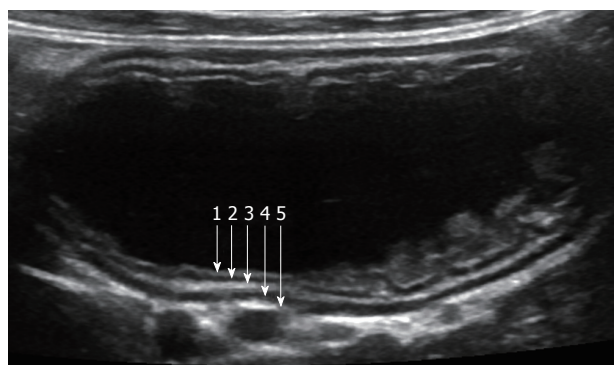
Normal small bowel. Ultrasound image of small bowel obtained after ingestion of water, using high-resolution linear probe. Five wall layers include: 1-mucosal interface with lumen (hyperechoic), 2-mucosa (hypoechoic), 3-submucosa (hyperechoic), 4-muscularis (hypoechoic), and 5-serosa (hyperechoic).
